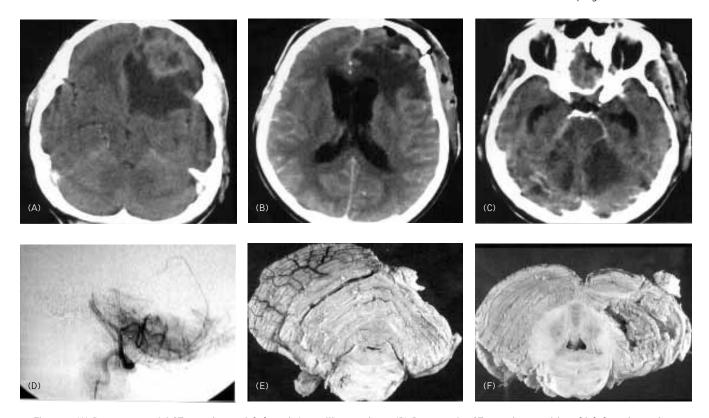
(A) Postcontrast axial CT scan shows a left frontal Aspergillus granuloma. (B) Postoperative CT scan shows excision of left frontal granuloma by a left frontal craniotomy. (C) Postoperative CT scan shows bilateral cerebellar and brainstem infarcts noted as hypointense areas.
